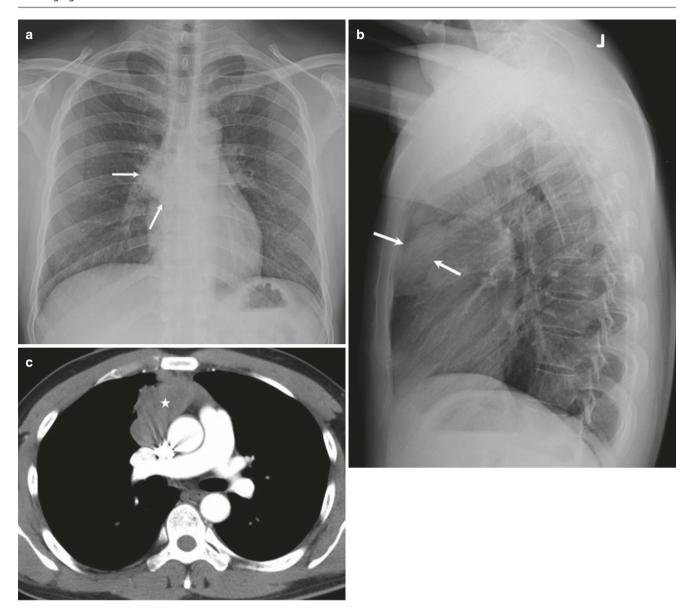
49-year-old man with thymoma. (a) Frontal radiograph shows a right hilar opacity (arrows) silhouetting the adjacent right heart border with "hilum overlay" sign present. (b) Lateral radiograph shows
